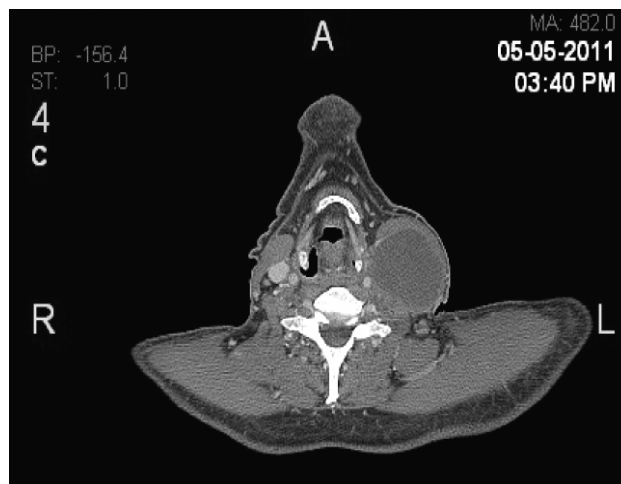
axial view CT scan of the neck showing bilateral lymphadenopathy with prominent large left level II, III and IV enlargement
